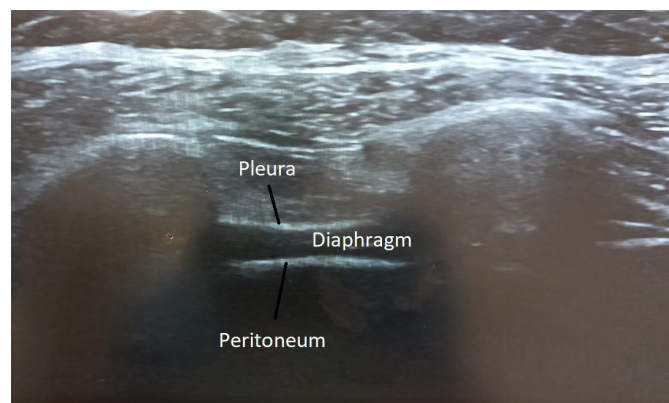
Diaphragmatic view in B-mode ultrasound
